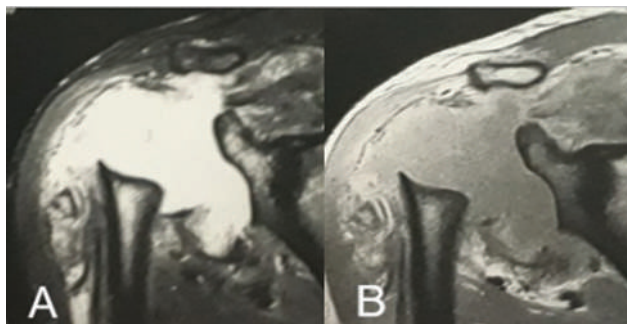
Magnetic resonance Imaging of the right shoulder in T2-weighted (A) and short tau inversion recovery (STIR) (B) sequence, in sagittal view, showing destruction of the humeral head, glenoid and rotator cuff tendons, with a voluminous adjacent fluid collection.
